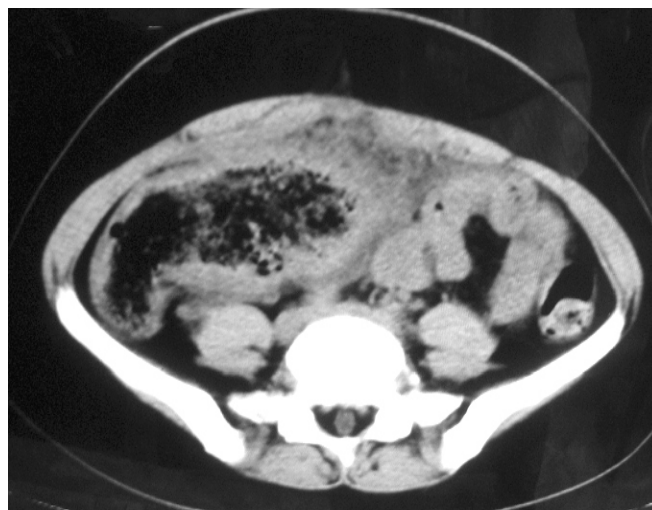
CT scan showing complex mass with a thick peripheral rim containing air bubbles with a mesh-like appearance
